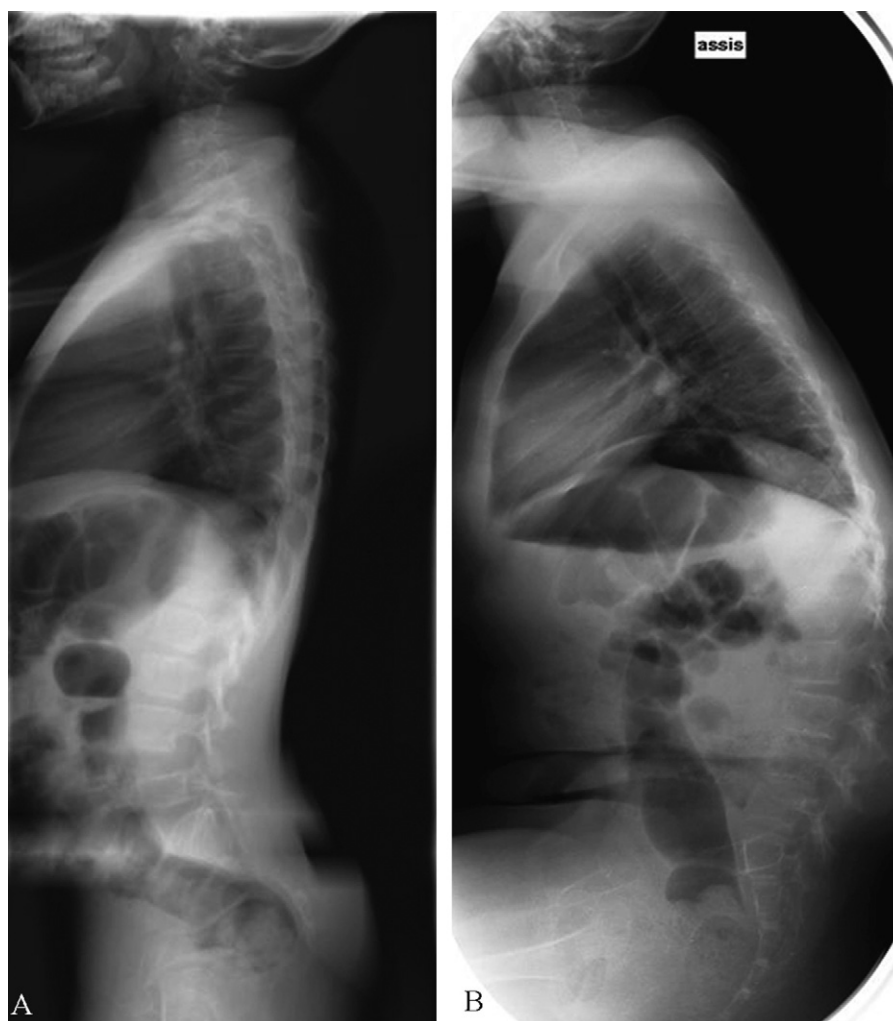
Evolution of postural hypotonia leading progressively to lumbar kyphosis in a boy with Duchenne muscular dystrophy. A. Lateral spinal X-ray, standing, age 8 years. B. Lateral spinal X-ray, seated, age 10 years.
